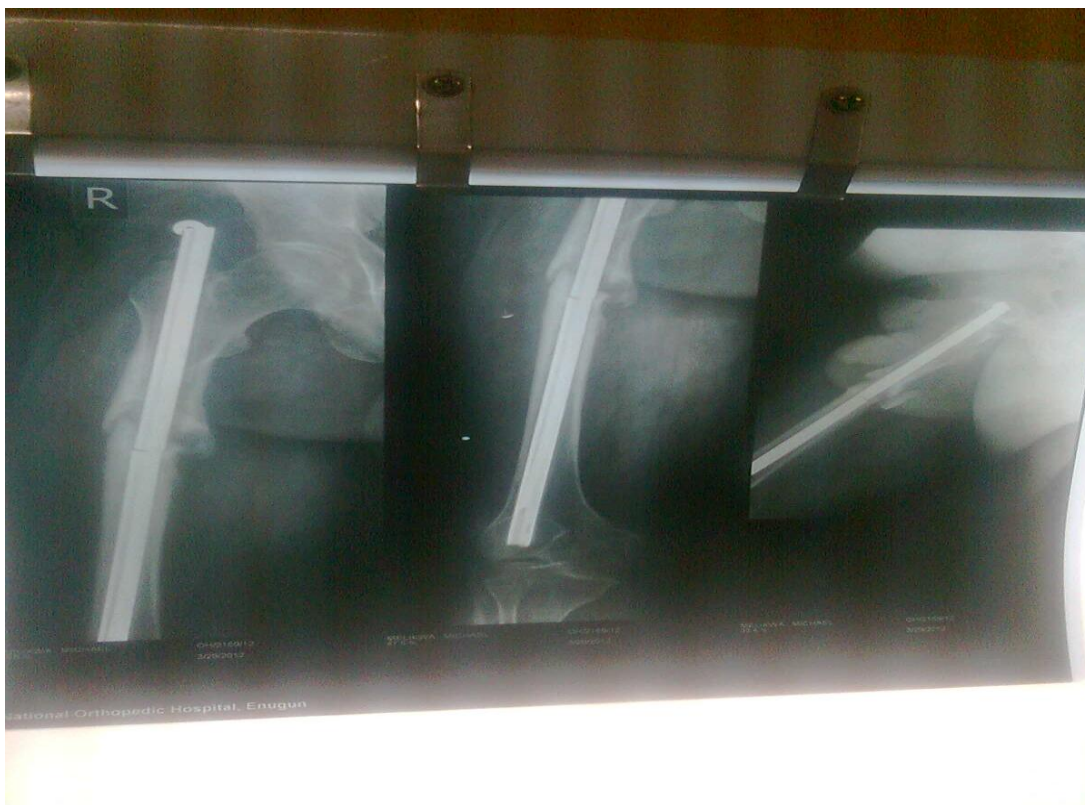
Pre-operative radiograph showing broken femoral nail.
